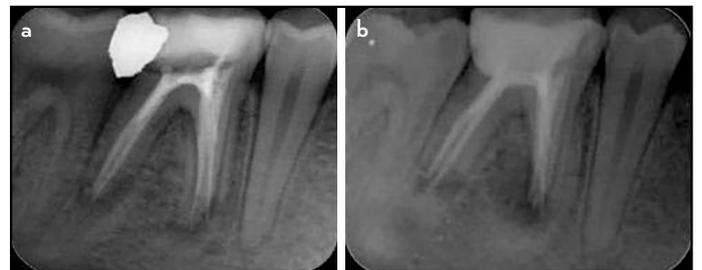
a-b. Images of a mandibular right first molar following endodontic treatment. The tooth was symptomatic at the follow-up appointment and both roots were classified as unsatisfactory healing. (a) The post-operative radiograph indicated periapical radiolucency in both roots. The mesial root revealed perforation of the apical third. (b) The 3-year follow-up radiograph showed that periapical radiolucency was still present in the distal root, with signs of external inflammatory root resorption. The periapical radiolucency in the mesial root increased in size
